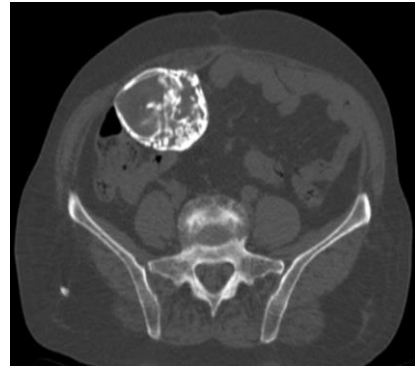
Plain CT axial section reveals: a well-defined calcified ovoid lesion, suggestive of a mummified fetus with detailed anatomy.
